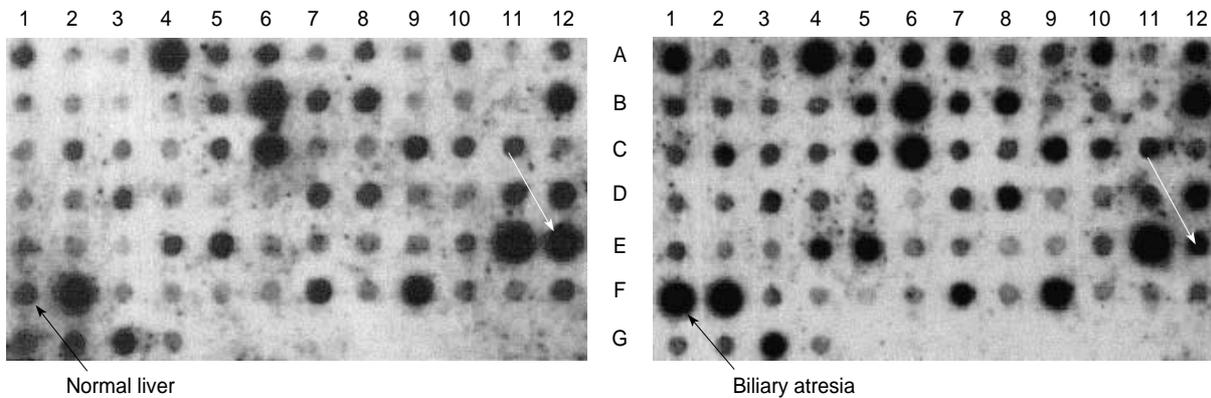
Results of DES in normal liver and biliary atresia liver tissues. EST dot blot panels were hybridized in ExpressHyb hybridization solution (Clontech, USA) with radioactive cDNA probe pools at the concentration of  $2 \times 10^6$  cpm/mL at 68°C for 1 hr. After hybridization, membranes were washed in  $2 \times$ SSC/0.05% SDS at room temperature for 40 min with two changes, followed by washes in  $0.1 \times$ SSC/0.1% SDS for 40 min with one change. Then the membranes were wrapped and exposed to X-ray film at -70°C for 3 weeks. Arrows indicate differentially expressed genes.
